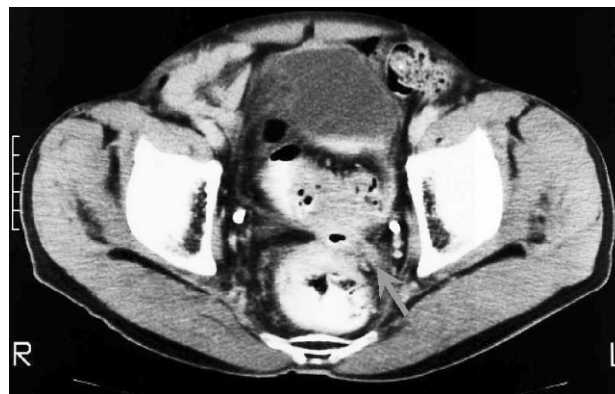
The patient was evaluated for invasion of the bilateral seminal vesicles by preoperative computed tomography (arrow). During surgery, we determined that the bilateral seminal vesicles were invaded, so a low anterior resection was done, and bilateral seminal vesicles were removed.
